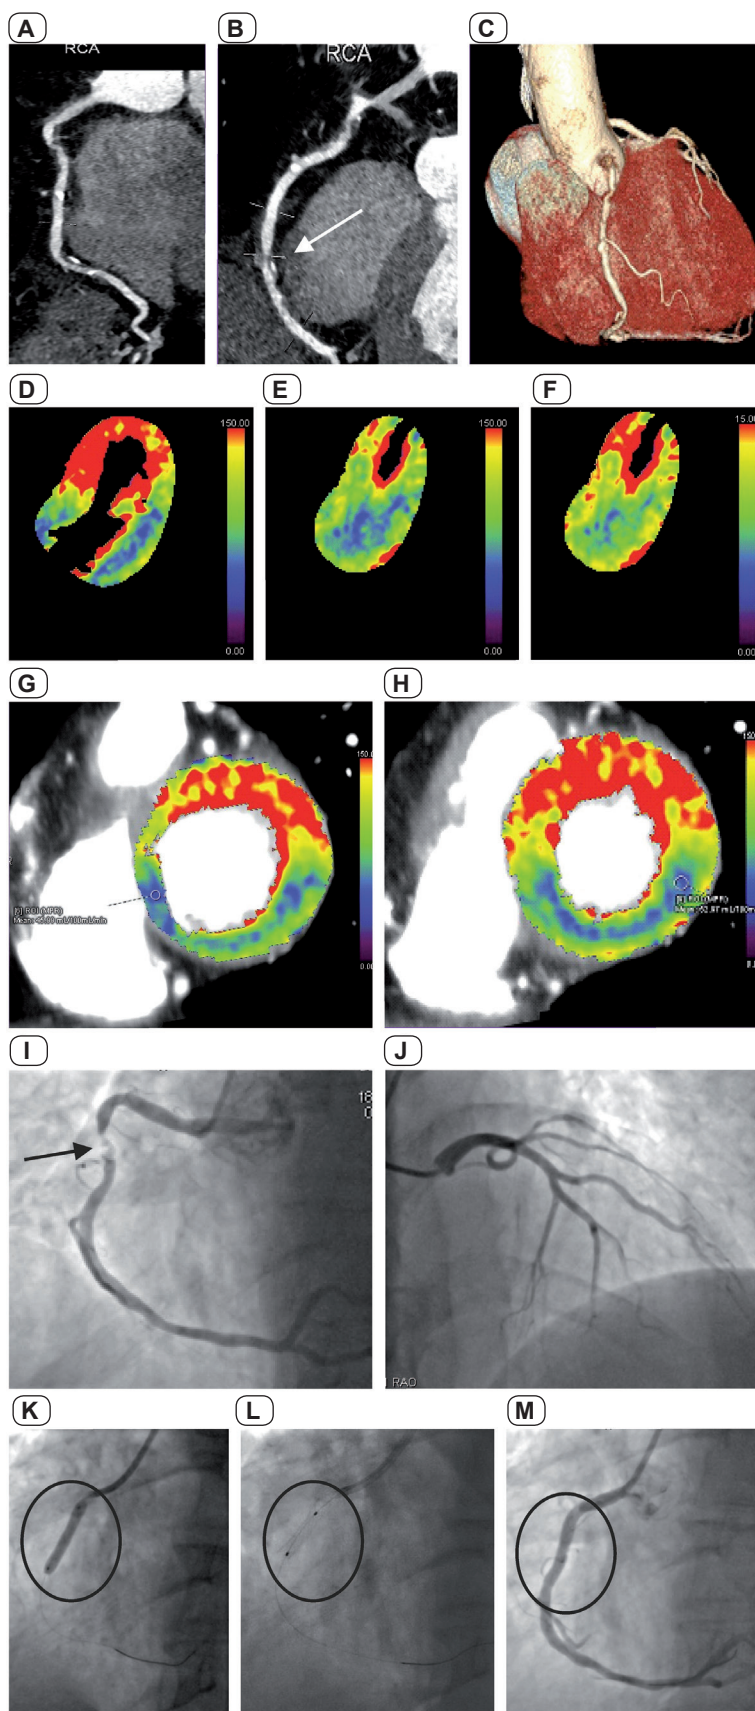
Myocardial perfusion imaging and invasive coronary angiography. CT (A-C) right coronary artery stenosis and (D-H) perfusion CT with hypoperfusion in examined region of right coronary artery images of representative patient subsequently indicated for (E-M) PTCA and (K-M) stent placement. CT, computerized tomography; PTCA, percutaneous transluminal coronary angioplasty. The dual source 3rd generation CT Somatom Force device (Siemens Healthcare GmbH) was used to acquire the images A-H. Figures are adopted from Gibarti et al. *Exp Ther Med.* 2023;25(5):192 with kind permission of Spandidos Publications.
